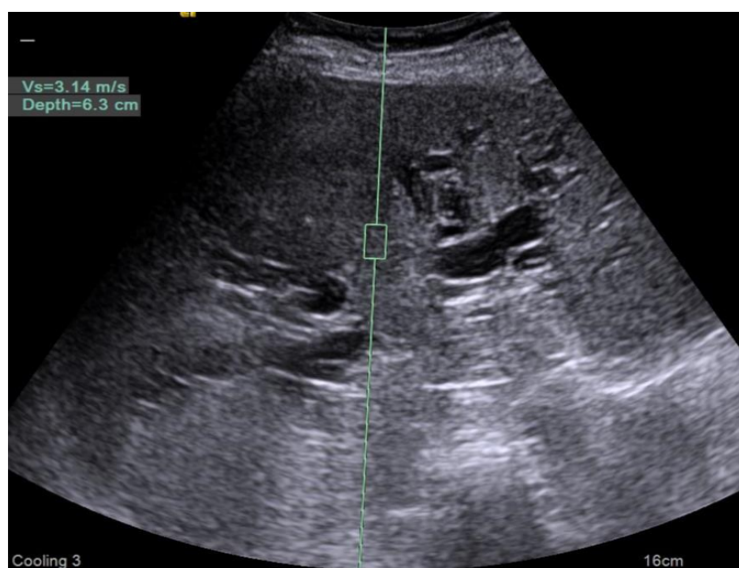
Ultrasound elastography in a cholangio-carcinoma
